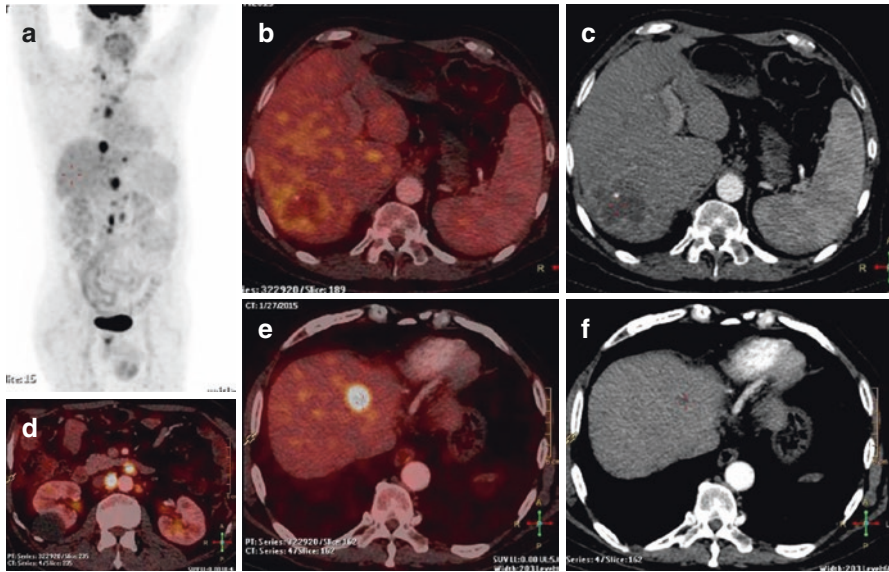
Case of intermediate HCC treated with TACE had clinical suspicion of recurrence in view of elevated tumor marker. FDG PET/CT revealed absence of uptake in the primary site (b—CECT and c), focal FDG uptake seen in two lesions in the liver (e, f) and retroperitoneal nodes (d) and mediastinal and supraclavicular (a, *arrow*) metastatic nodal disease
